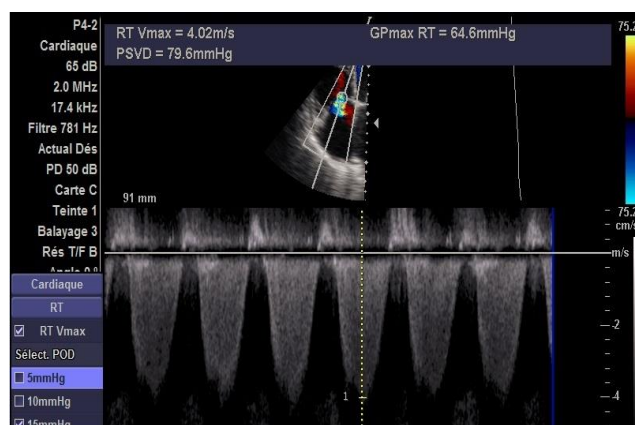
Continuous Doppler over the tricuspid valve showing pulmonary hypertension 79.6 mmHg.
